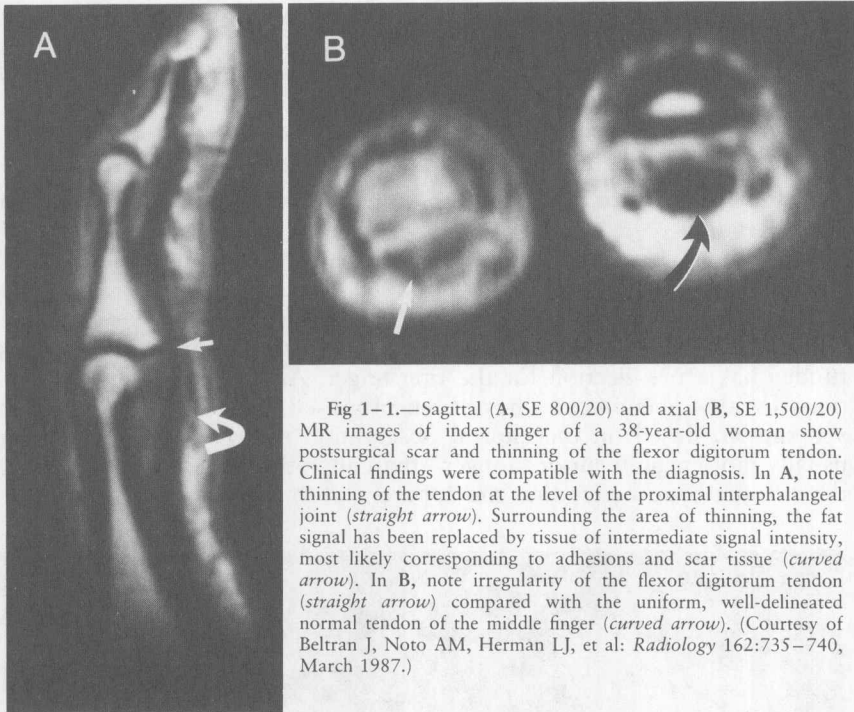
Sagittal (A, SE 800/20) and axial (B, SE 1,500/20) MR images of index finger of a 38-year-old woman show postsurgical scar and thinning of the flexor digitorum tendon. Clinical findings were compatible with the diagnosis. In A, note thinning of the tendon at the level of the proximal interphalangeal joint (*straight arrow*). Surrounding the area of thinning, the fat signal has been replaced by tissue of intermediate signal intensity, most likely corresponding to adhesions and scar tissue (*curved arrow*). In B, note irregularity of the flexor digitorum tendon (*straight arrow*) compared with the uniform, well-delineated normal tendon of the middle finger (*curved arrow*). (Courtesy of Beltran J, Noto AM, Herman LJ, et al: *Radiology* 162:735–740, March 1987.)
